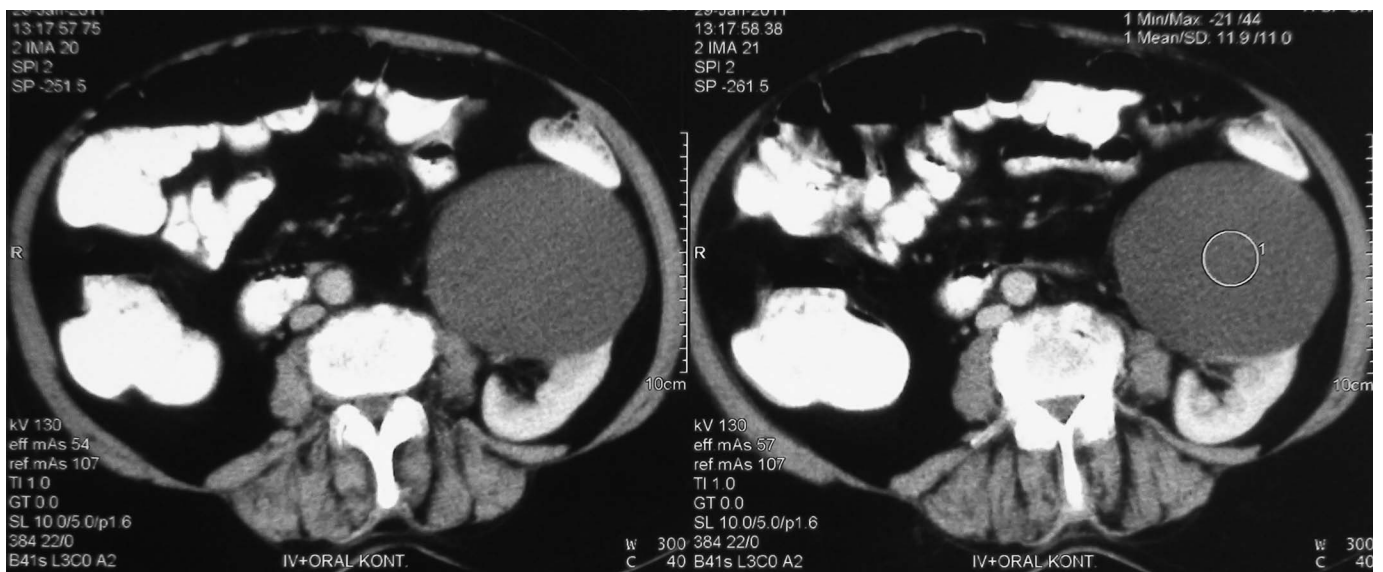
The CT scan shows a perihilar renal cyst.
